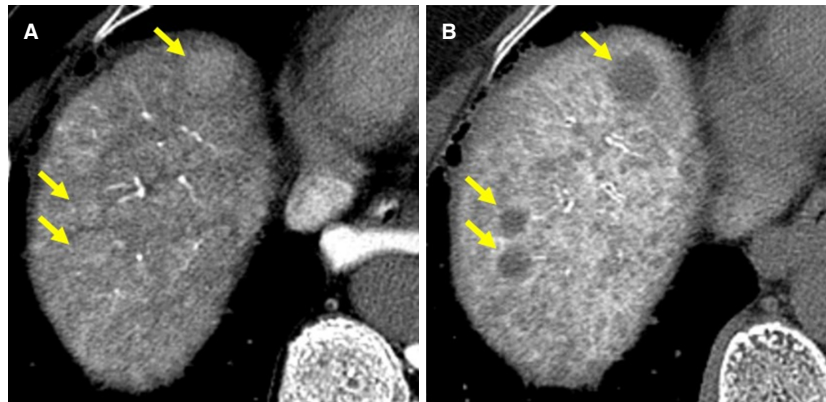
Example of high grade dysplastic nodule in cirrhotic liver. A: on CT during arterial portography, there are isodense nodule compared to background liver (arrows), which represent nodular portal flow is preserved; B: on CT during hepatic arteriography, these nodules show hypodensity compared to the background liver (arrows), which indicate the nodular arterial supply is decreased. This hypovascular pattern represents relatively benign nature nodules under multistep hepatocarcinogenesis
